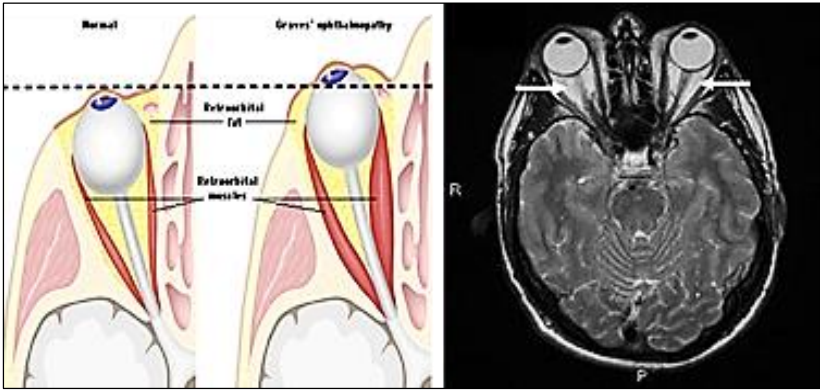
Different between normal graves ophthalmopathy and CT image
